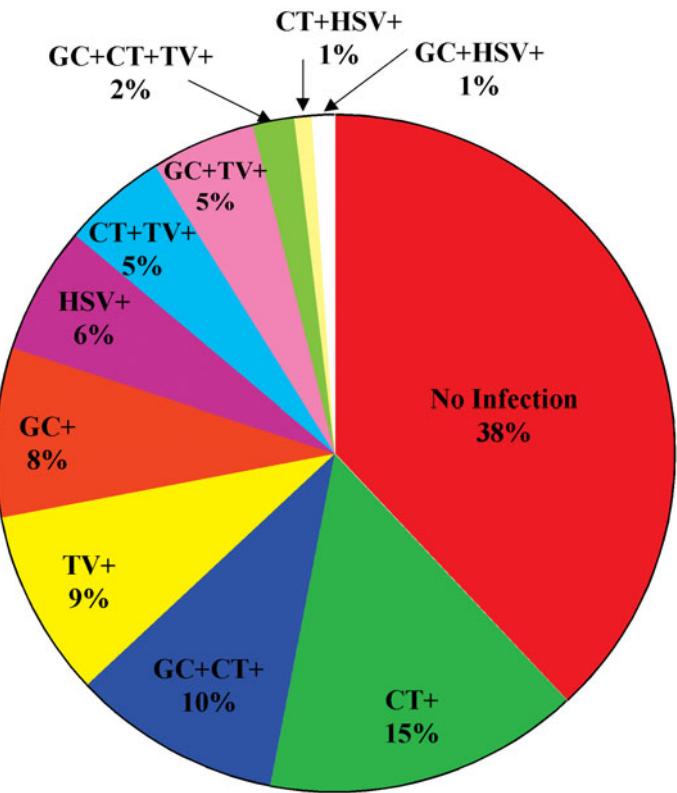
Among 779 consecutive female STD clinic patients, 182 (23.4%) had signs of endocervical mucopus. This pie chart shows the percentage of those with endocervical mucopus no cervical infection, or cervical infection by *C. trachomatis* (CT), *N. gonorrhoeae* (GC), herpes simplex virus (HSV), or *T. vaginalis* (TV).
